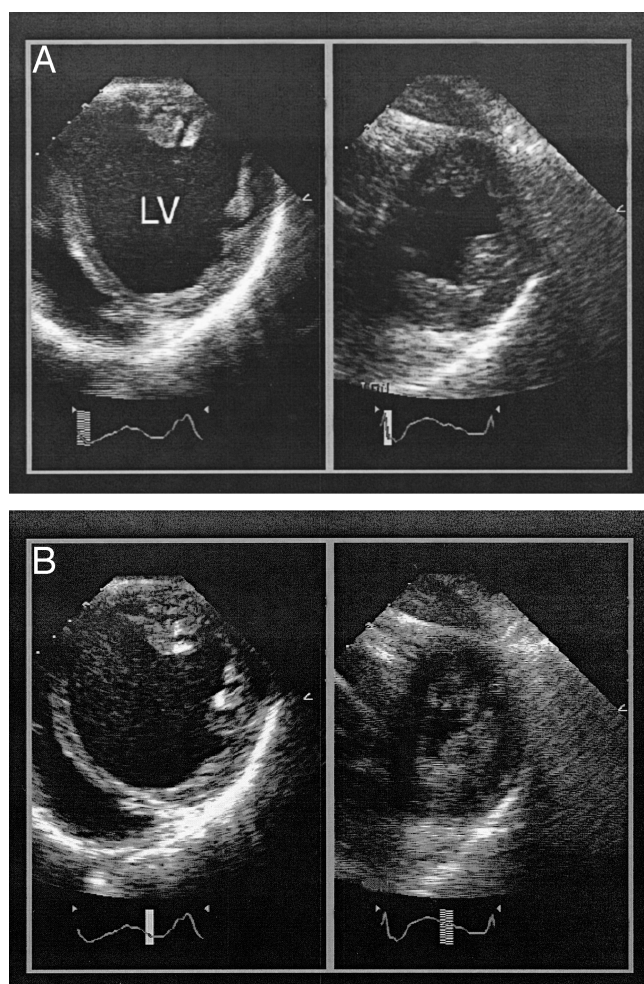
A, two echocardiograms are shown in stop action at end-diastole. Both are transgastric short-axis views of the left ventricle, and both were recorded during hypotension (mean arterial pressure, 50 mm Hg). Left, before heart transplantation; right, a few minutes after. Notice that the pretransplantation left ventricle (LV) has a much greater end-diastolic volume than the new ventricle. B, the corresponding end-systolic stop action images are shown. Notice that the new ventricle has ejected a much greater fraction of its end-diastolic volume. Low cardiac output was the principal cause of the hypotension before transplantation whereas inappropriately low systemic vascular resistance was the principal cause after transplantation.
